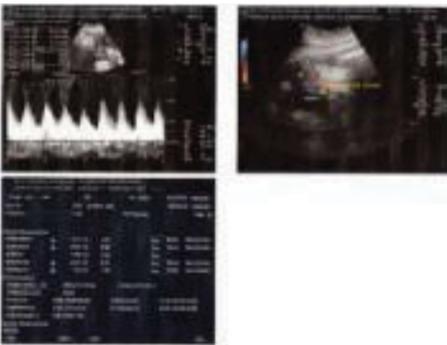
Fetal ultrasound biometry measurements.
